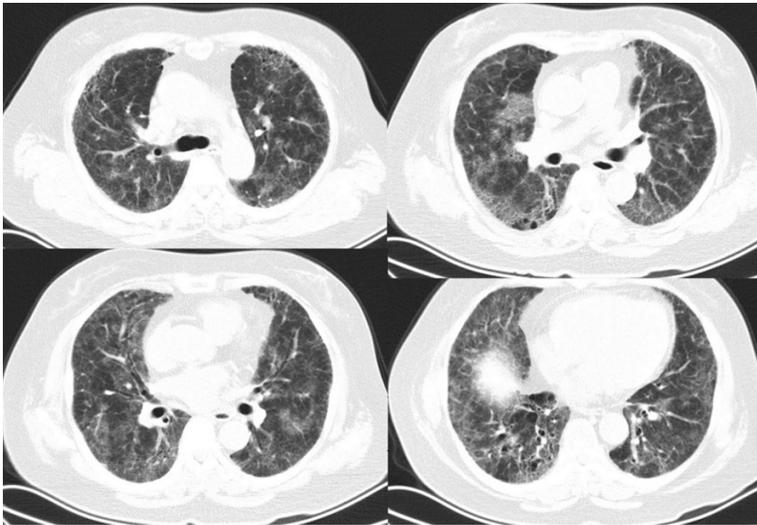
Computed tomography scan of the proband (II.1) at the onset of acute exacerbation shows diffuse areas of ground glass attenuations superimposed on underlying fibrotic opacities throughout both lungs.
